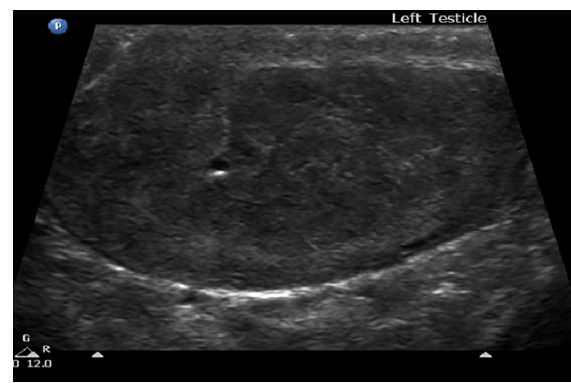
Ultrasound of the left testicle showing hyperechoic areas.
